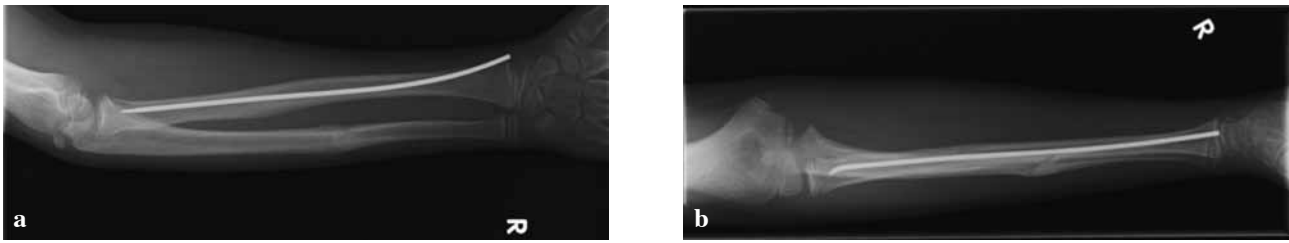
4 months post operative radiographs
